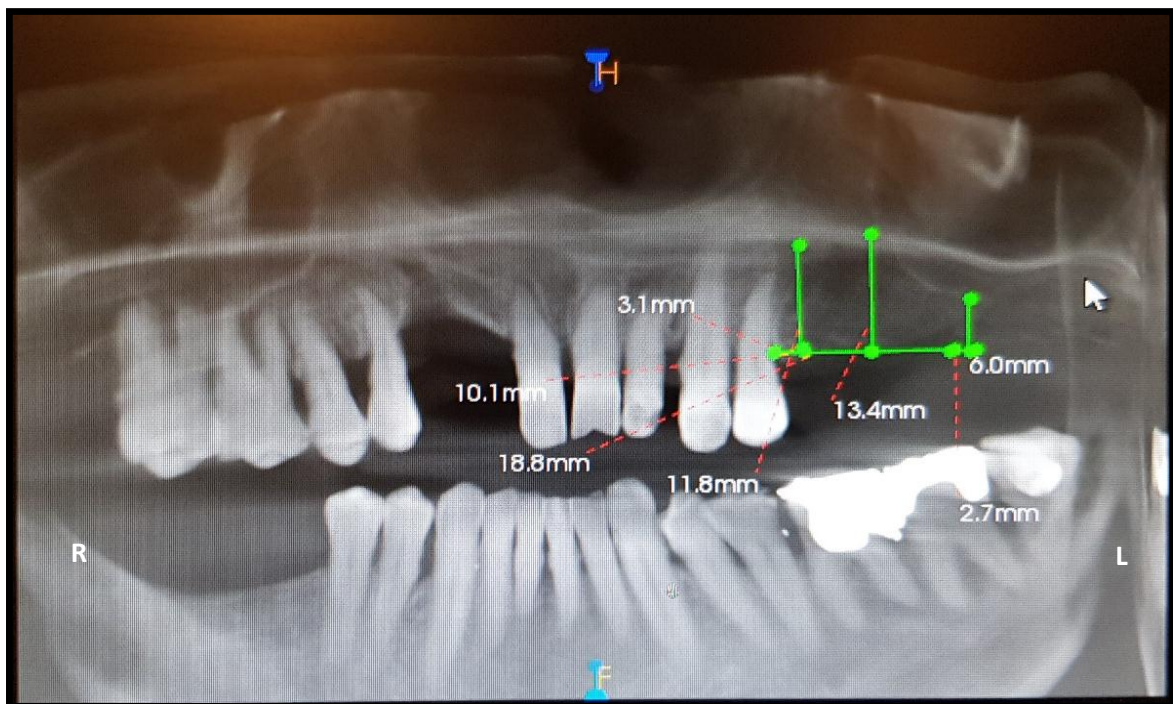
Preoperative CBCT scan (panoramic view) revealing the subantral distance (SAD) at different points to determine the lowest height and where SL should be performed.
